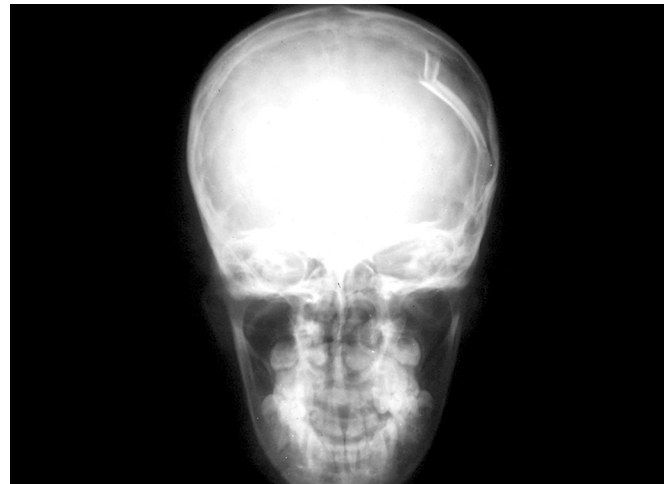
Depressed fracture. Frontal radiograph shows the parallel dense lines due to depressed bone fragments and associated lucency due to absence of bone
